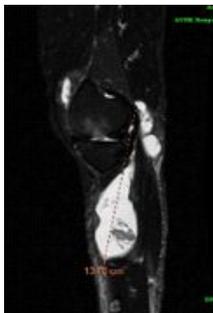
MRI image of the swelling
